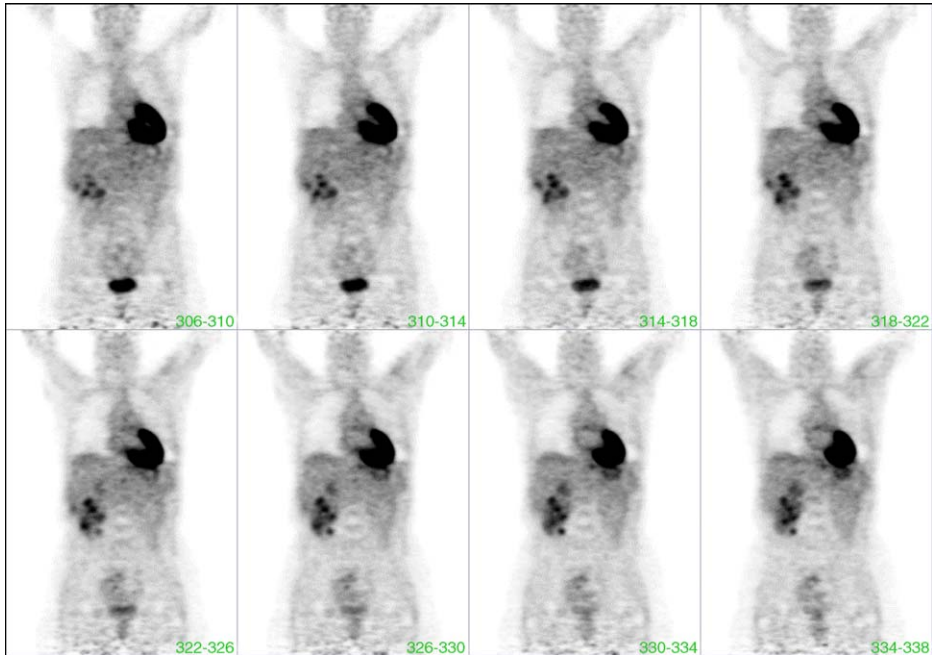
Coronal views of FDG-PET show no multiple focal areas of increased FDG uptake in the right lobe of liver and perirenal region suggestive of metastases.
